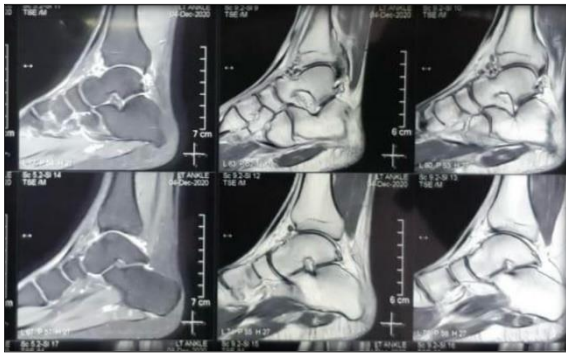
Pre-op MRI showing multiple loose bodies anterior to ankle joint
